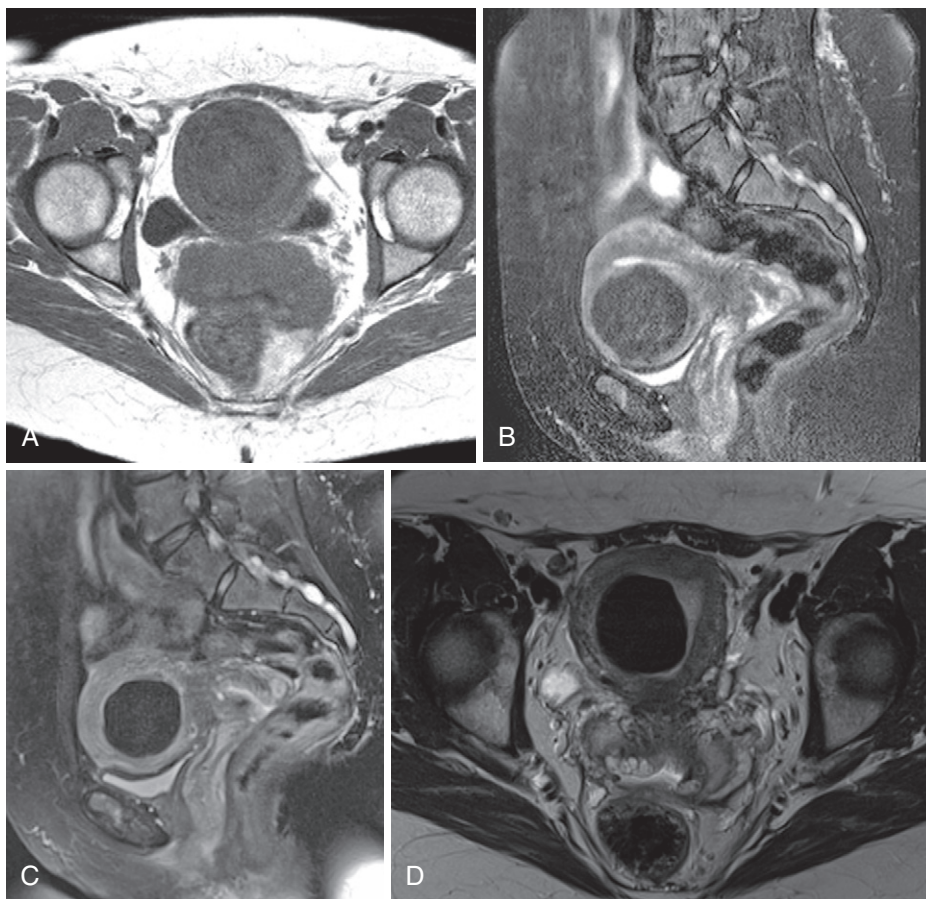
Fibroid hypovascularity postembolization. Axial T1-weighted (A) and sagittal T2-weighted (B) images of a large intramural fibroid with the typical homogeneous hypointensity before embolization contrast with signal characteristics indicating hemorrhagic degeneration after embolization—marked T2 hypointensity as seen on sagittal T2-weighted fat-suppressed (C) and axial T2-weighted (D) images and T1 hyperintensity on axial gradient echo T1-weighted (E) and fat-suppressed gradient echo T1-weighted (F) images and absence of enhancement—compare pregadolinium (E) with postgadolinium (G) images.
